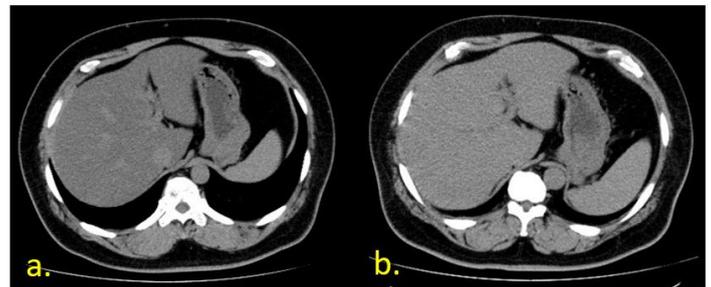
Changes in fatty liver for abdominal CT scan
